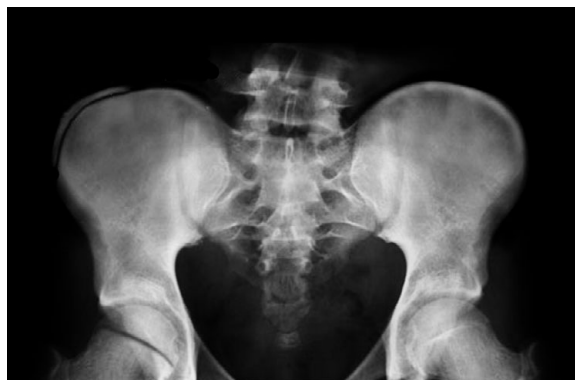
Anteroposterior (AP) radiograph pelvis skeletally immature patient
